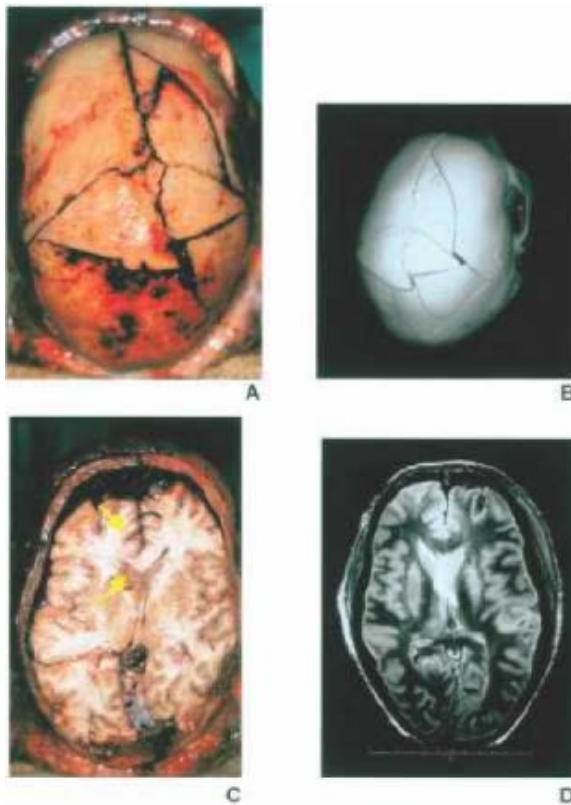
Fracture of the cranial vault in a 27-year-old patient due to a fall from a tree. (a): Autopsy image; (b): three-dimensional reconstruction of the bone table; (c): axial autopsy slice; (d): axial T2 MRI image.
